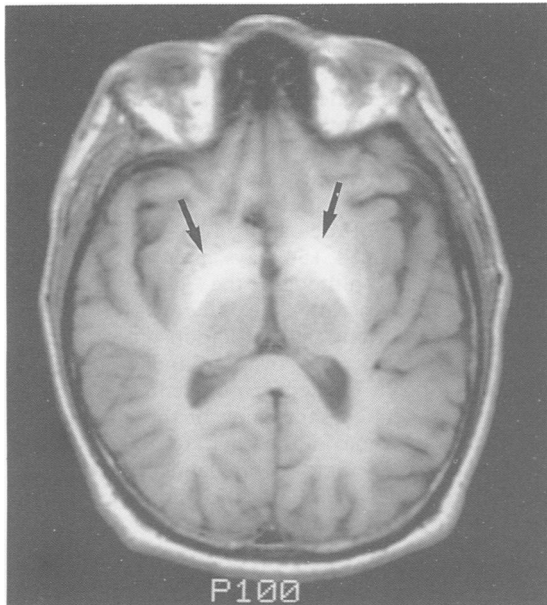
Initial MRI. Top; axial T1 weighted image (TR/TE, 500/15 ms) at the level of the basal ganglia. Increased signal intensity in the globus pallidus (arrows) that is bilateral and symmetrical reflects shortened T1 relaxation due the paramagnetic effect of Mn. Bottom; T2 weighted image (TR/TE, 2500/70 ms) is unremarkable. Some decreased signal intensity in the basal ganglia is normally expected for this age of patient.
